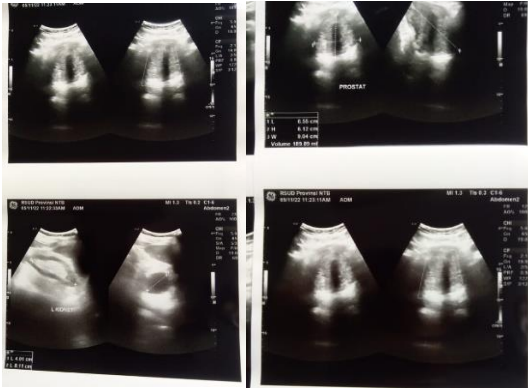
Ultrasonography of the prostate showing an enlarged prostate with prostate volume of 189.89 cc
